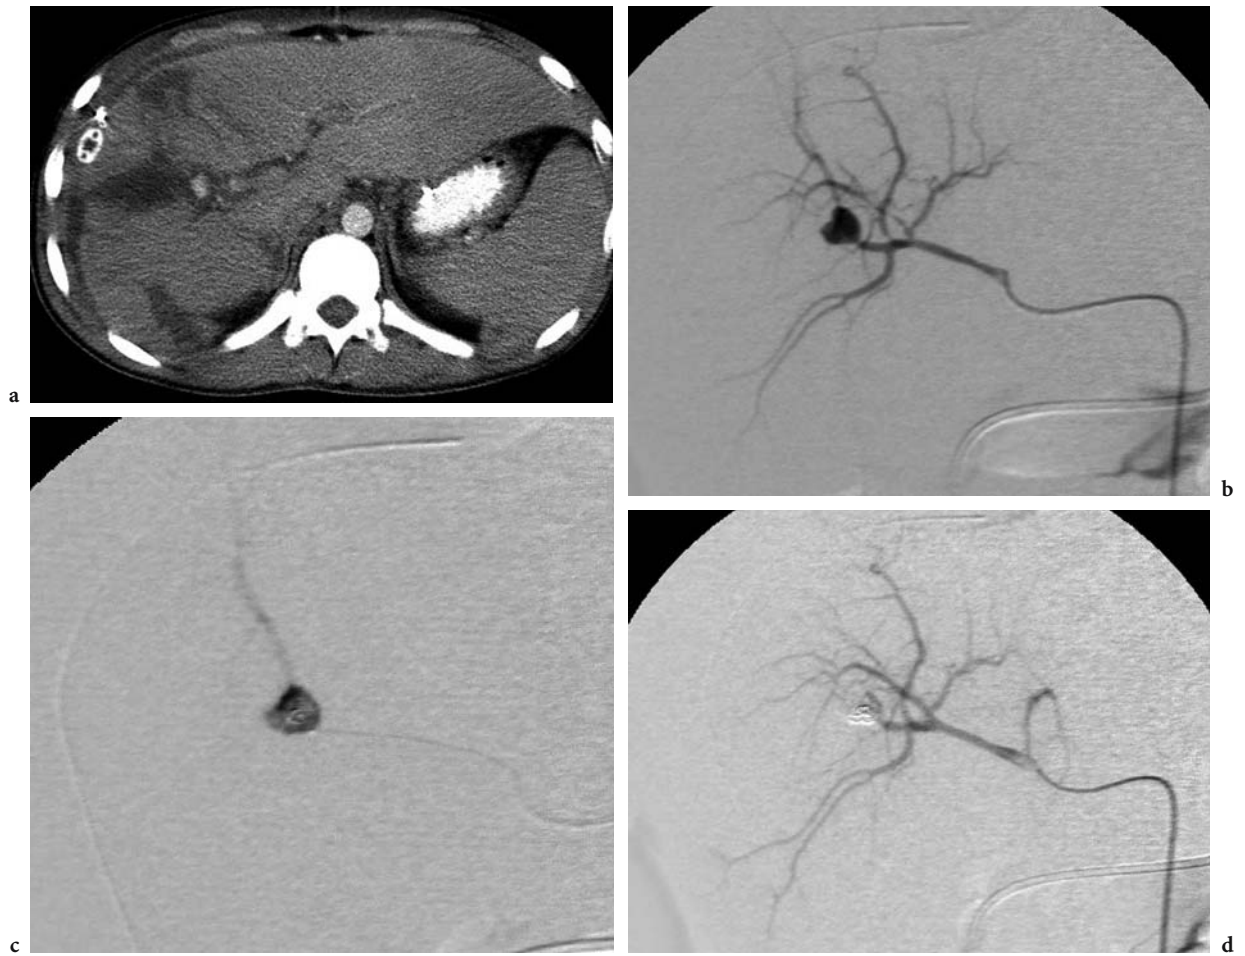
Liver trauma in a 15-year-old boy. a CT-scan revealed the presence of an arterial pseudoaneurysm. b Selective catheterization of the hepatic artery confirmed the pseudoaneurysm. c With a coaxial system (Tracker: Renegade) we overpass the pseudoaneurysm and occlude the exit branch with a coil. Then, we occlude the pseudoaneurysm with glue followed by the occlusion of the afferent artery by a coil. d Control angiogram revealed a complete occlusion of the pseudoaneurysm
